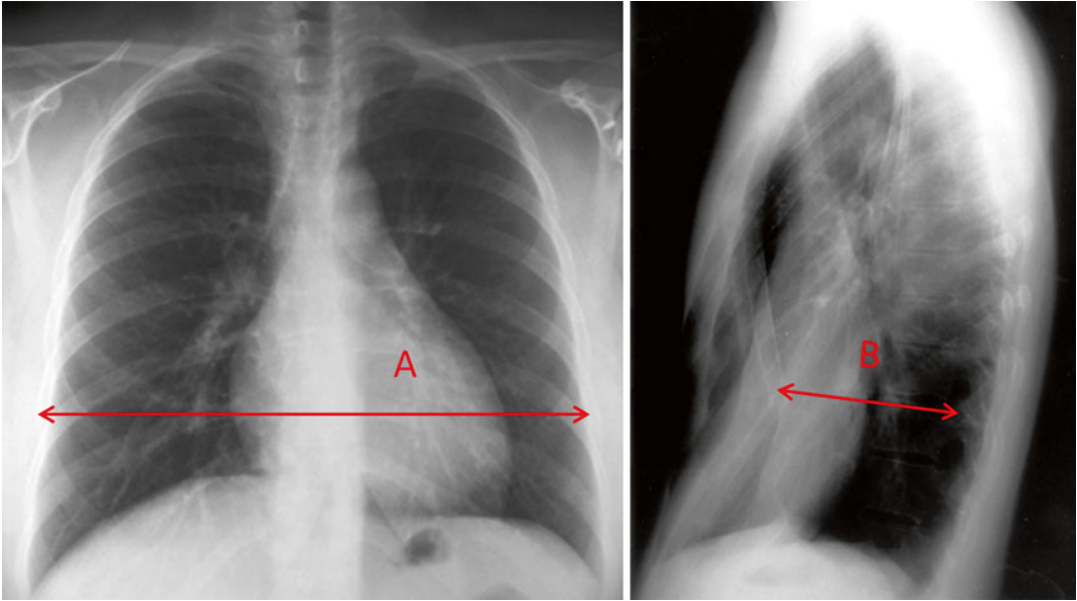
Chest-X-Ray Haller Index measurement on two-view chest radiography. (A) The point of most posterior projection of the sternum is identified, and the distance between
